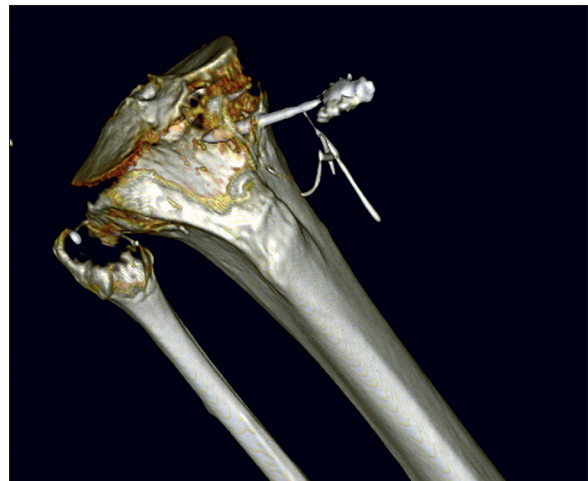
Intraosseous needle view in CT scan
